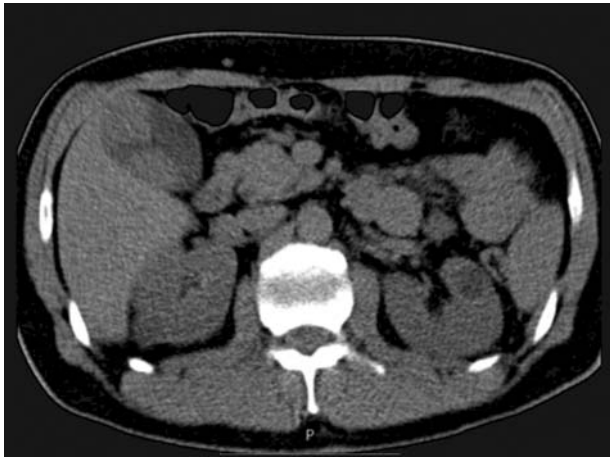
Abdominal CT scan with gallbladder metastases
